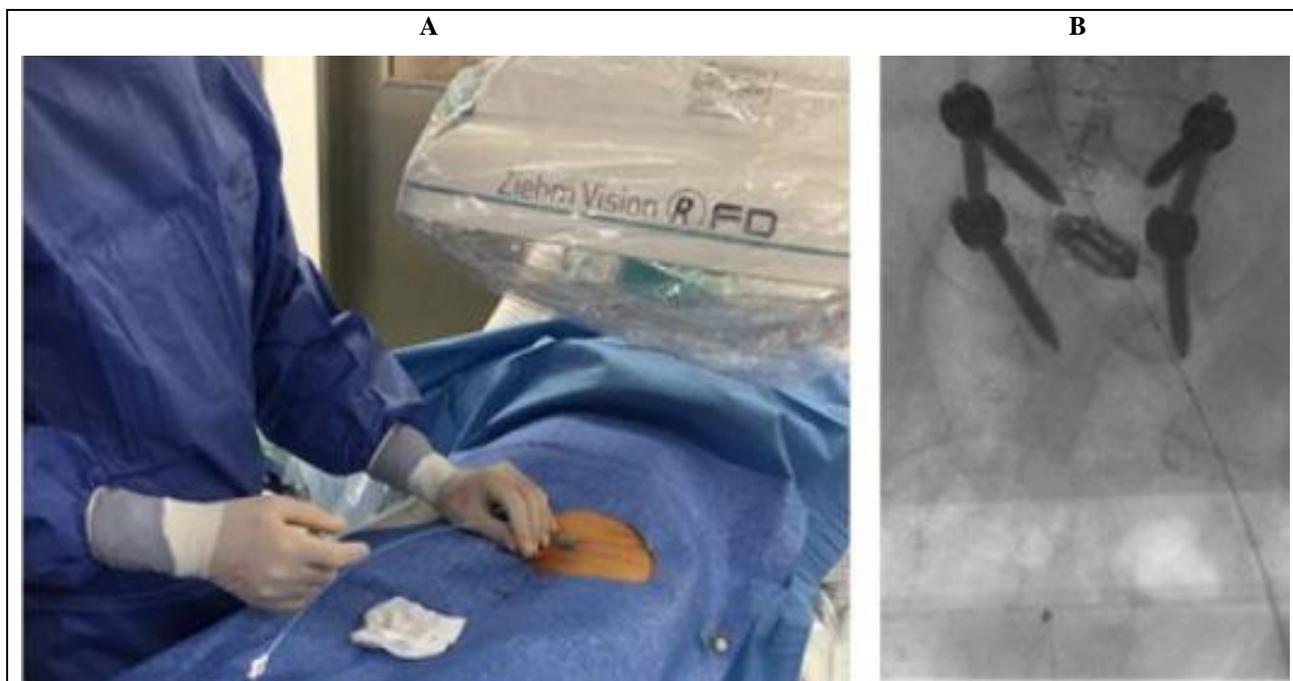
Patient in supine position. (A): Left common femoral vein access and placement of a balloon catheter via 8-French sheath; (B): X-ray visualization of the correct balloon position (the points mark the position of the balloon).
